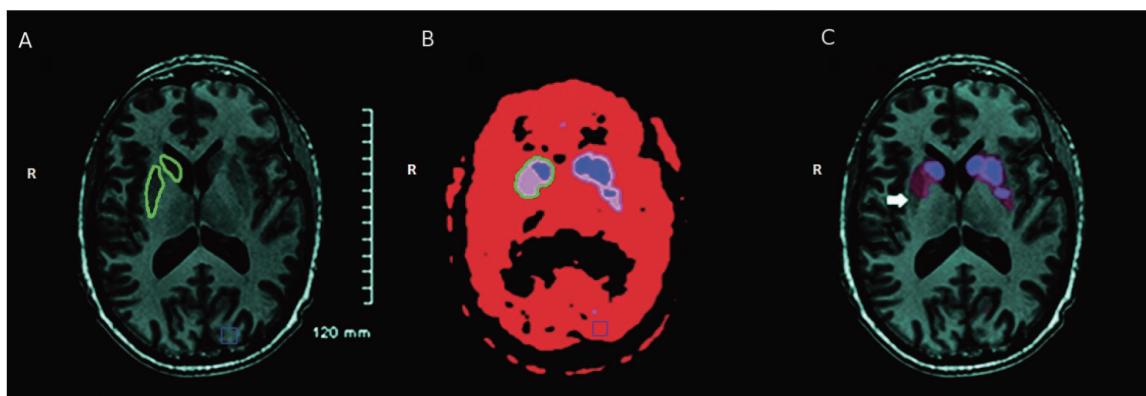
This is the T1 weighted MRI (A), FDOPA PET (B), and fused MRI/PET (C) of a patient with PD with left sided predominant symptoms. The right striatal ROIs are demarcated by a green line on the MRI and PET images. The blue lines demarcate the occipital lobe ROIs. The white arrow marks the area of the right posterior putamen that is incorporated into the MRI based ROI, but not the PET-based ROI. ROIs based solely on the FDOPA PET image can fail to accurately incorporate the entire anatomical reference. The right side of each image is marked with an R.
